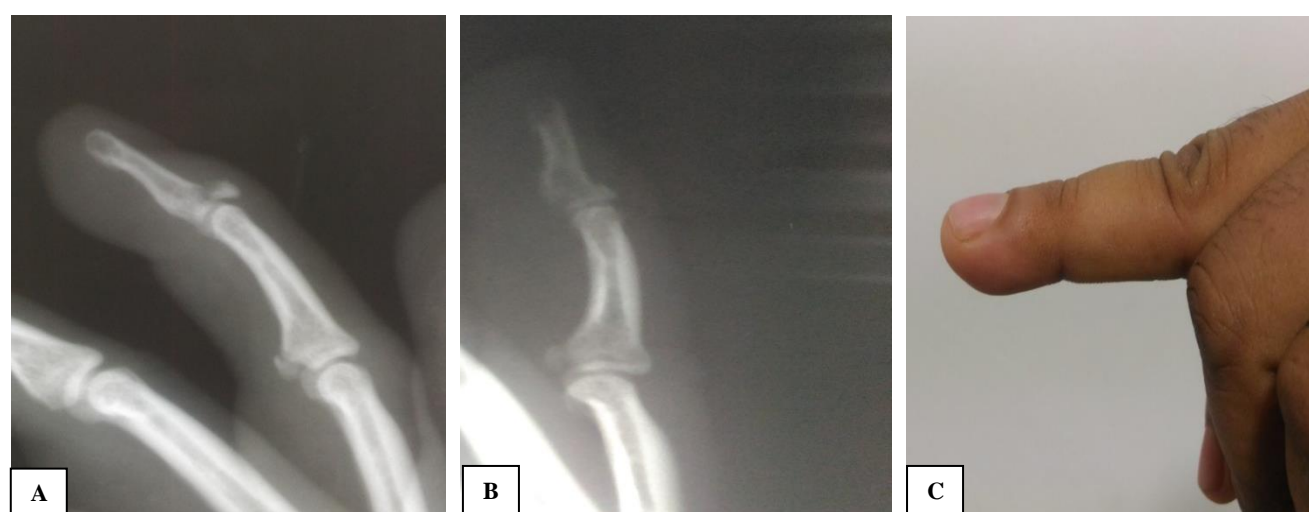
(A) Radiographs showing mallet fracture of the ring finger; (B) Postoperative radiograph showing anatomical reduction after wire removal; (C) Clinical photograph of full extension of the DIP joint at 3 months after follow up.
